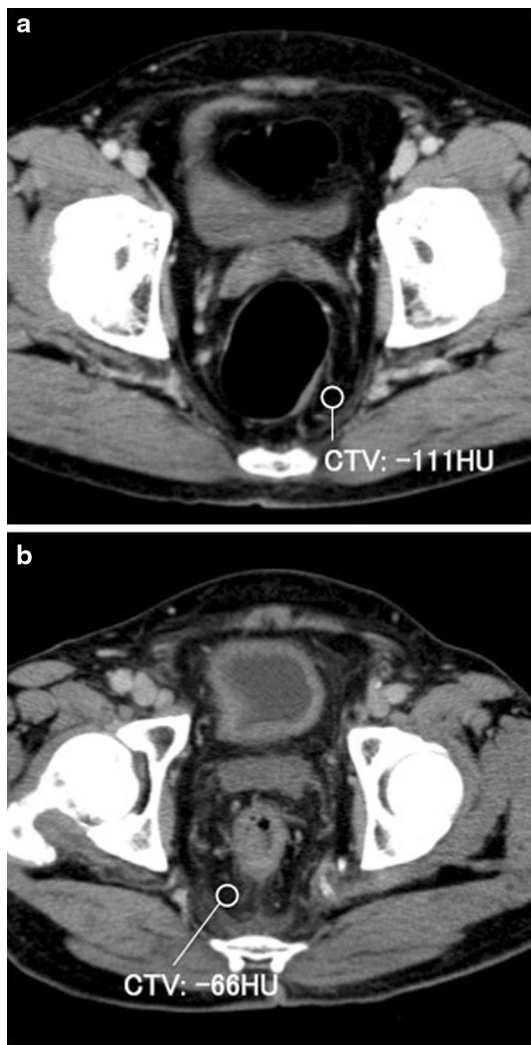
Computed tomography value of the mesorectum. The computed tomography value (CTV) of the mesorectum was relatively low (-111HU) in Case 1 (a) and high (-66HU) in Case 2 (b)
